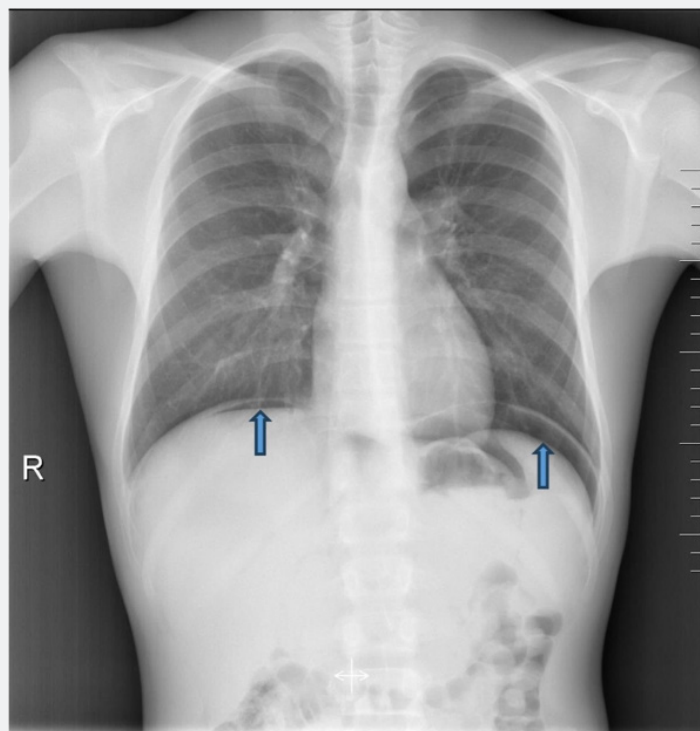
Chest radiograph showing subdiaphragmatic free air beneath both hemidiaphragms (arrows), consistent with residual postoperative pneumoperitoneum.
